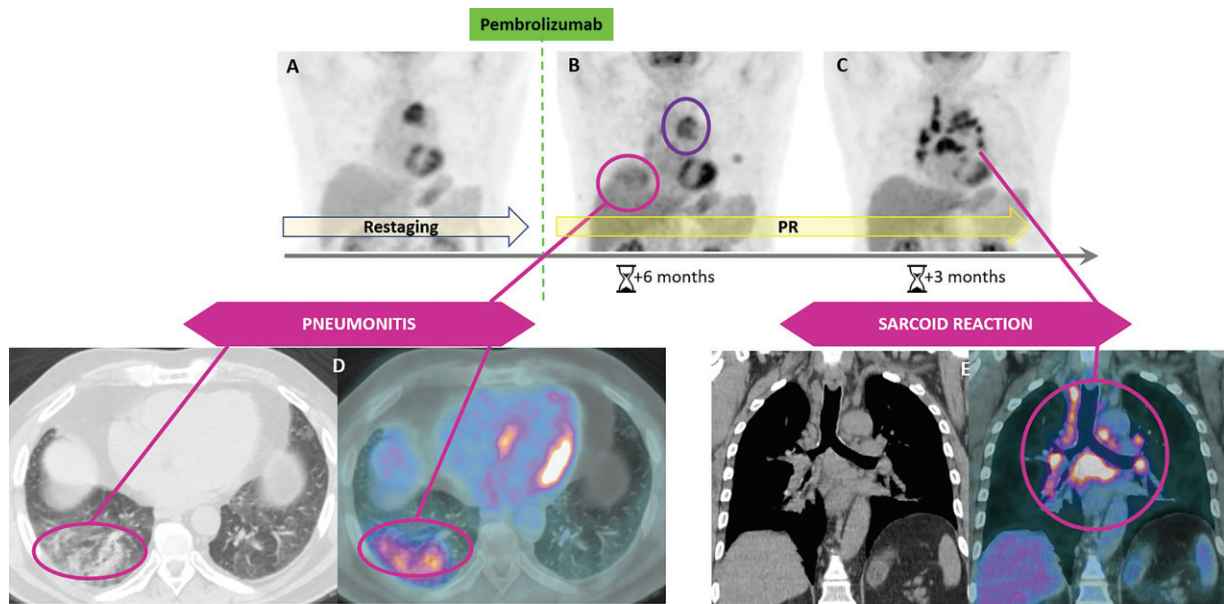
Immunotherapy-related pneumonitis and sarcoid reaction in a 72-year-old man with thymic carcinoma. *A*, FDG PET image for restaging shows the primary lesion. *B*, *C*, Images after pembrolizumab therapy show a partial response (PR) (purple oval), associated with the appearance of mild and diffuse ground-glass opacities (GGOs) in the lower right lung (pink circle) and emergence of enlarged mediastinal nodes with moderate hypermetabolism, suggestive of pneumonitis and sarcoid reaction, respectively. *D*, Axial CT (left) and FDG PET/CT (right) images show the GGOs (pink ovals). *E*, Coronal CT (left) and FDG PET/CT (right) images show the enlarged mediastinal nodes (pink circle).
